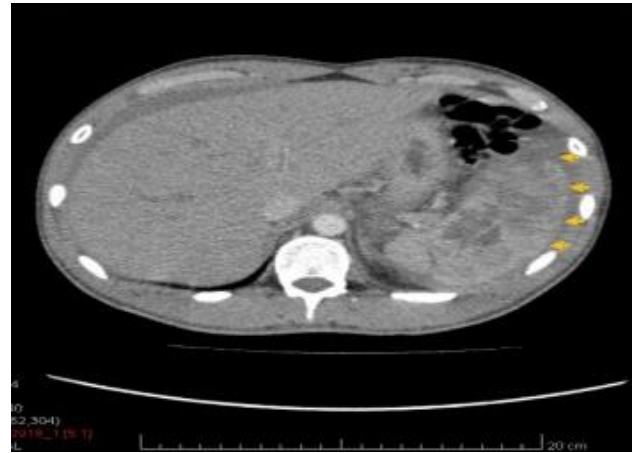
CT Axial splenic laceration with splenic hematoma.
